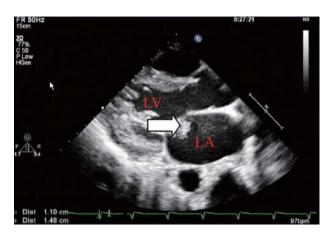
Transthoracic echocardiography demonstrated a large section of vegetation on the anterior leaflet of the mitral valve (1.2*0.9cm) (arrow).
